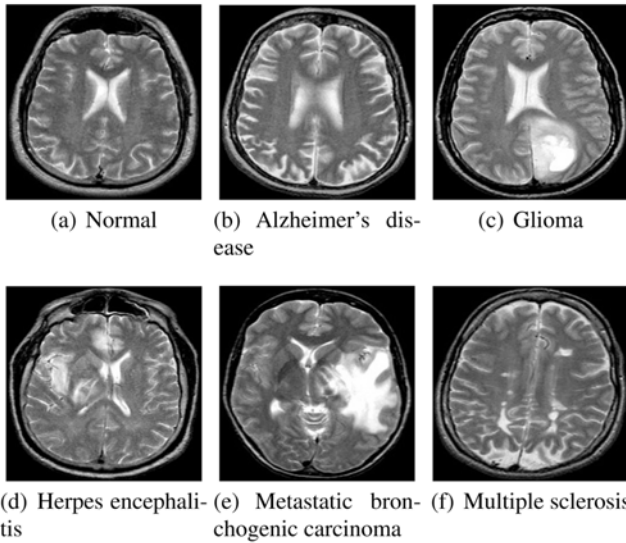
Sample brain MR images in the AANLIB database.
